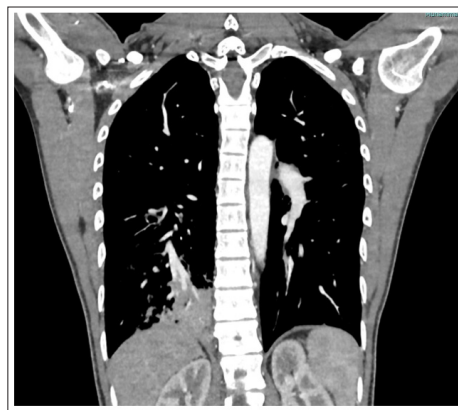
Initial CT scan (Coronal Image) of the Chest Showing a Consolidation in the Right Lower Lobe
